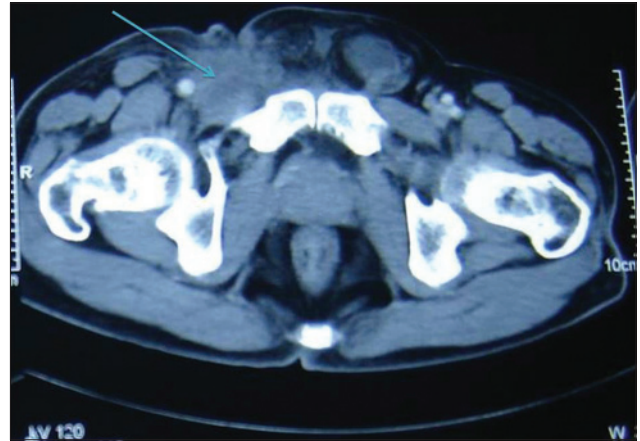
Contrast-enhanced computed tomography of pelvis showing right inguinal nodal mass (marked with arrow) infiltrating femoral vein
